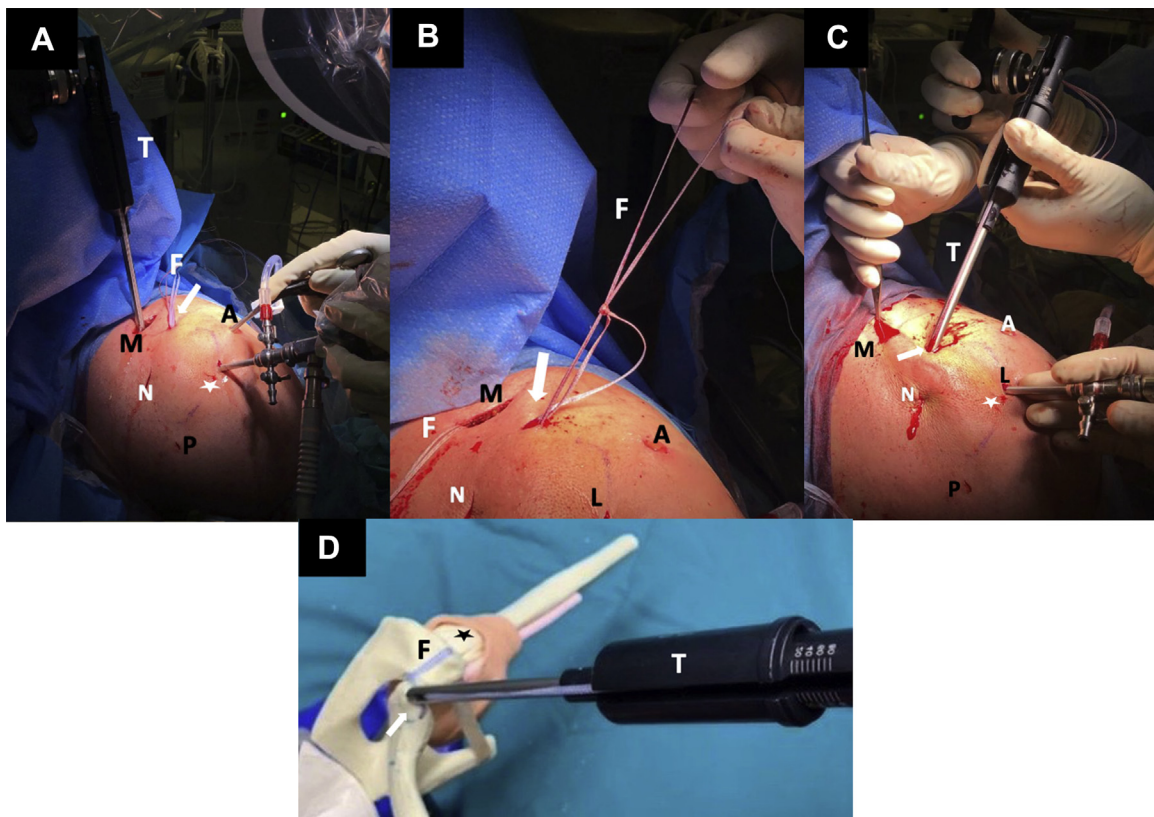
Superior view of the right shoulder; patient is in the beach chair position. Coracoclavicular and acromioclavicular FiberTape Cerclage sutures tying and tensioning. (A) Vertical coracoclavicular tensioning using the tensioner under X-ray anteroposterior view control. (B) Premanual tension on the preassembled racking hitch knot tails. Reduction and fixation of the dynamic posterior clavicle translation with the tensioner. (C) Manual reduction of the posterior AC joint, horizontal displacement with a gentle separator instrument, while the AC joint cerclage sutures are adjusted and tensioned with a tensioner. (D) Final tension of the FTC-s obtained with the tensioner (model). Arrow indicates anterior clavicle skin incision; star indicates lateral acromial skin incision. (A, anterior portal; AC, acromioclavicular; C, coracoid; D, drill; F, FiberTape Cerclage sutures; L, lateral portal; M, mini-open clavicular approach; N, Neviaser zone; Ni, looped nitinol wire; P, posterior arthroscopic portal.)
